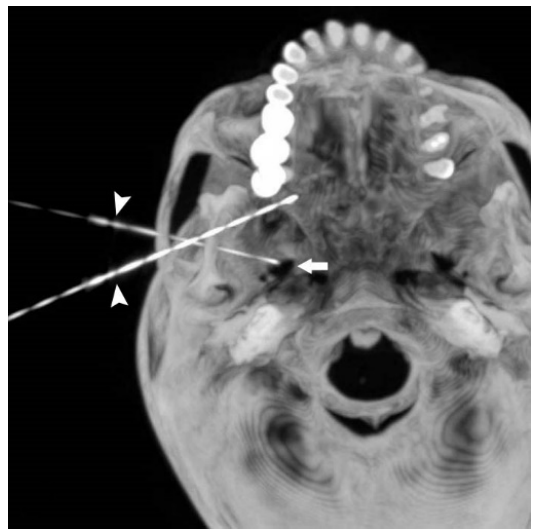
The maximal intensity projection (MIP) CT showing the needle (White arrowhead) tip just nearby the foramen ovale (FO) (White arrow).
